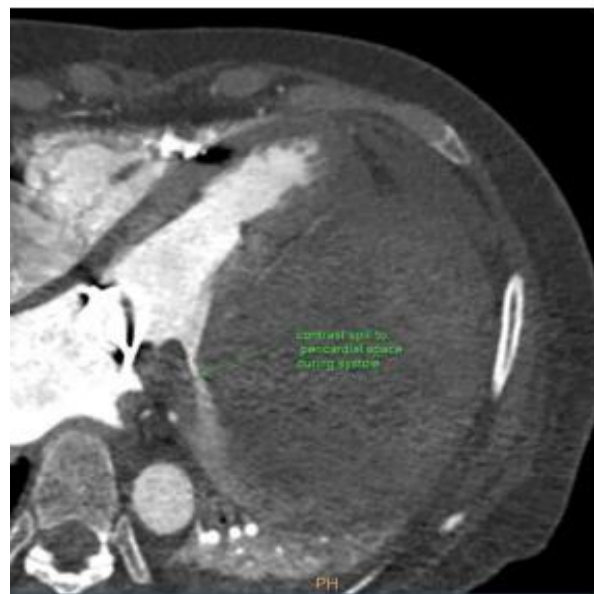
Cardiac CT showed significant massive large pericardial effusion due to LV wall rupture (contrast extravasation from intrachamber to pericard) near to prosthetic mitral valve (Type I LV Wall rupture).
